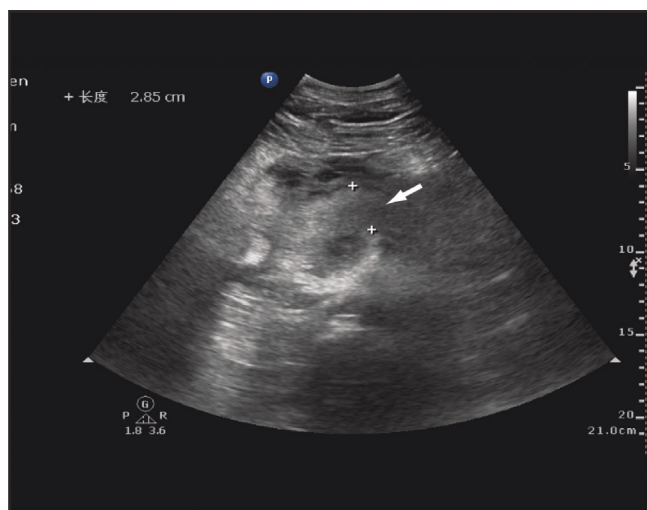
Ultrasound image shows pancreatic enlargement (arrow).
